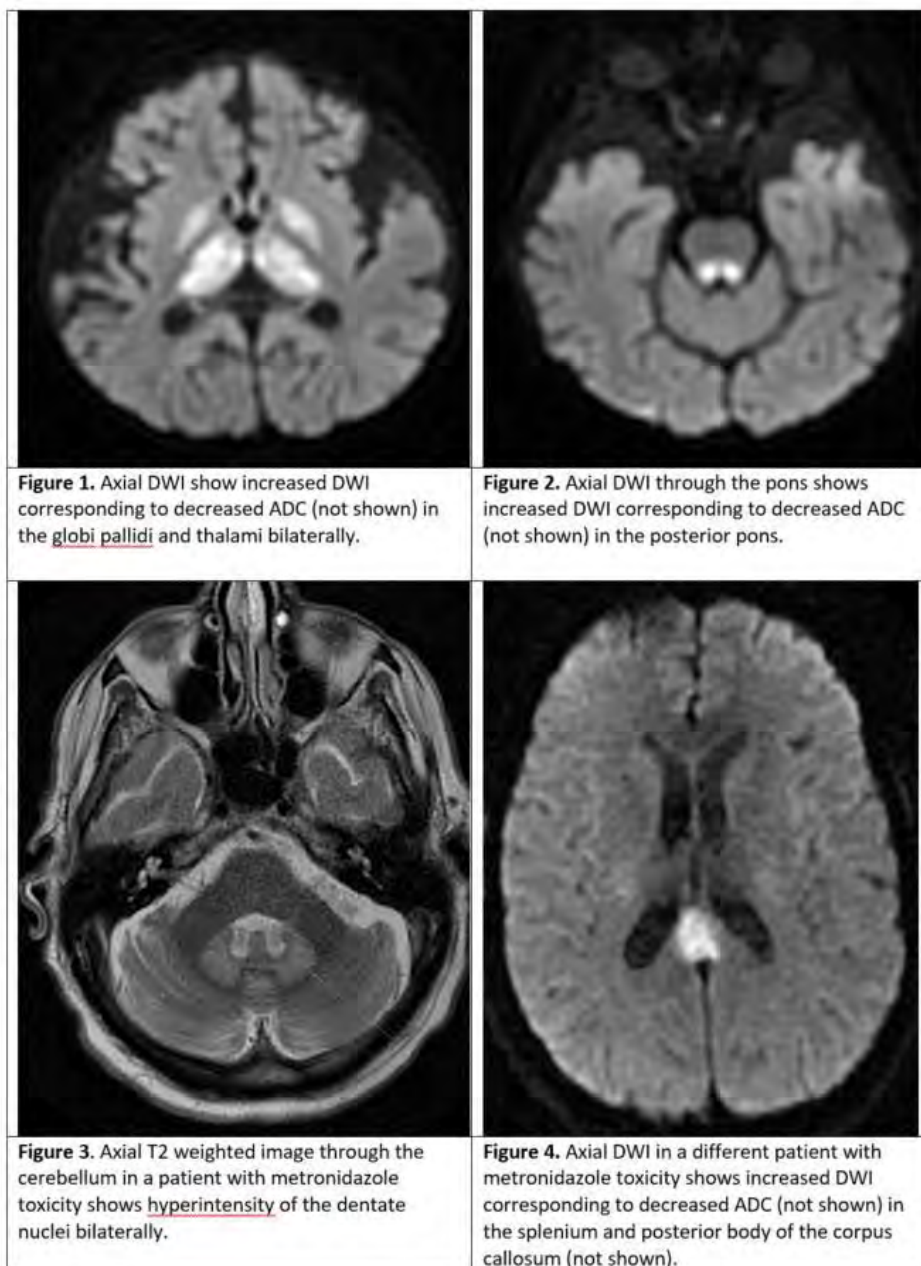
Axial DWI show increased DWI corresponding to decreased ADC (not shown) in the globi pallidi and thalami bilaterally.
